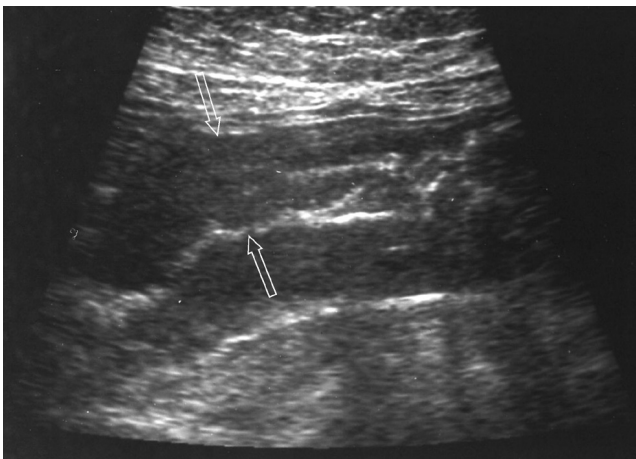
Transverse sonography of gastric antrum shows gastric wall thickening (mean thickness, 9.2 mm) with focal disruption of the stratification of gastric wall (open arrows). The gastric antrum of this patient was identified as gastric ulcer in the immediate endoscopy.
